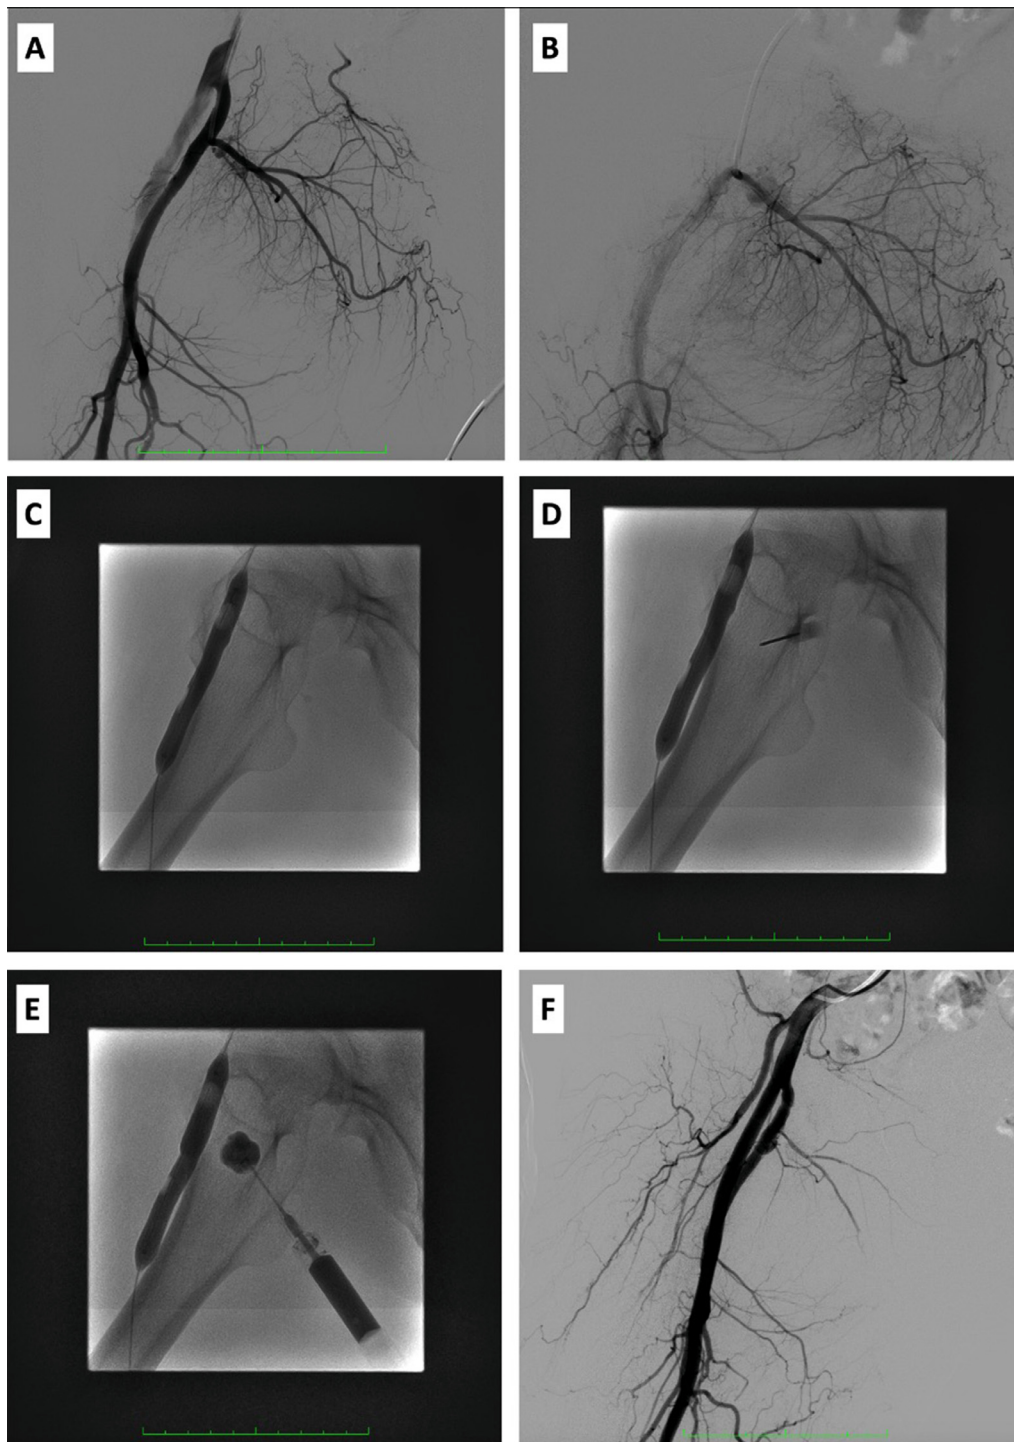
Selective right femoral angiography (A) and (B) showed a pseudoaneurysm of right deep femoral artery. (C) An EverCross 0.035" balloon of 8 x 60 mm (PTA Balloon Catheter Medtronic AVE, Santa Rosa, CA, EE. UU) was inflated in front of the pseudoaneurysm's neck to avoid the connection between the pseudoaneurysm and the parent artery. (D) The pseudoaneurysm sac was punctured under ultrasound guidance (not shown) by a needle 18G x 2 1/2". (E) Injection of NBCA into the pseudoaneurysm's sac under fluoroscopy guidance. (F) The final control angiography of the right common femoral artery confirmed no flow into the pseudoaneurysm.
